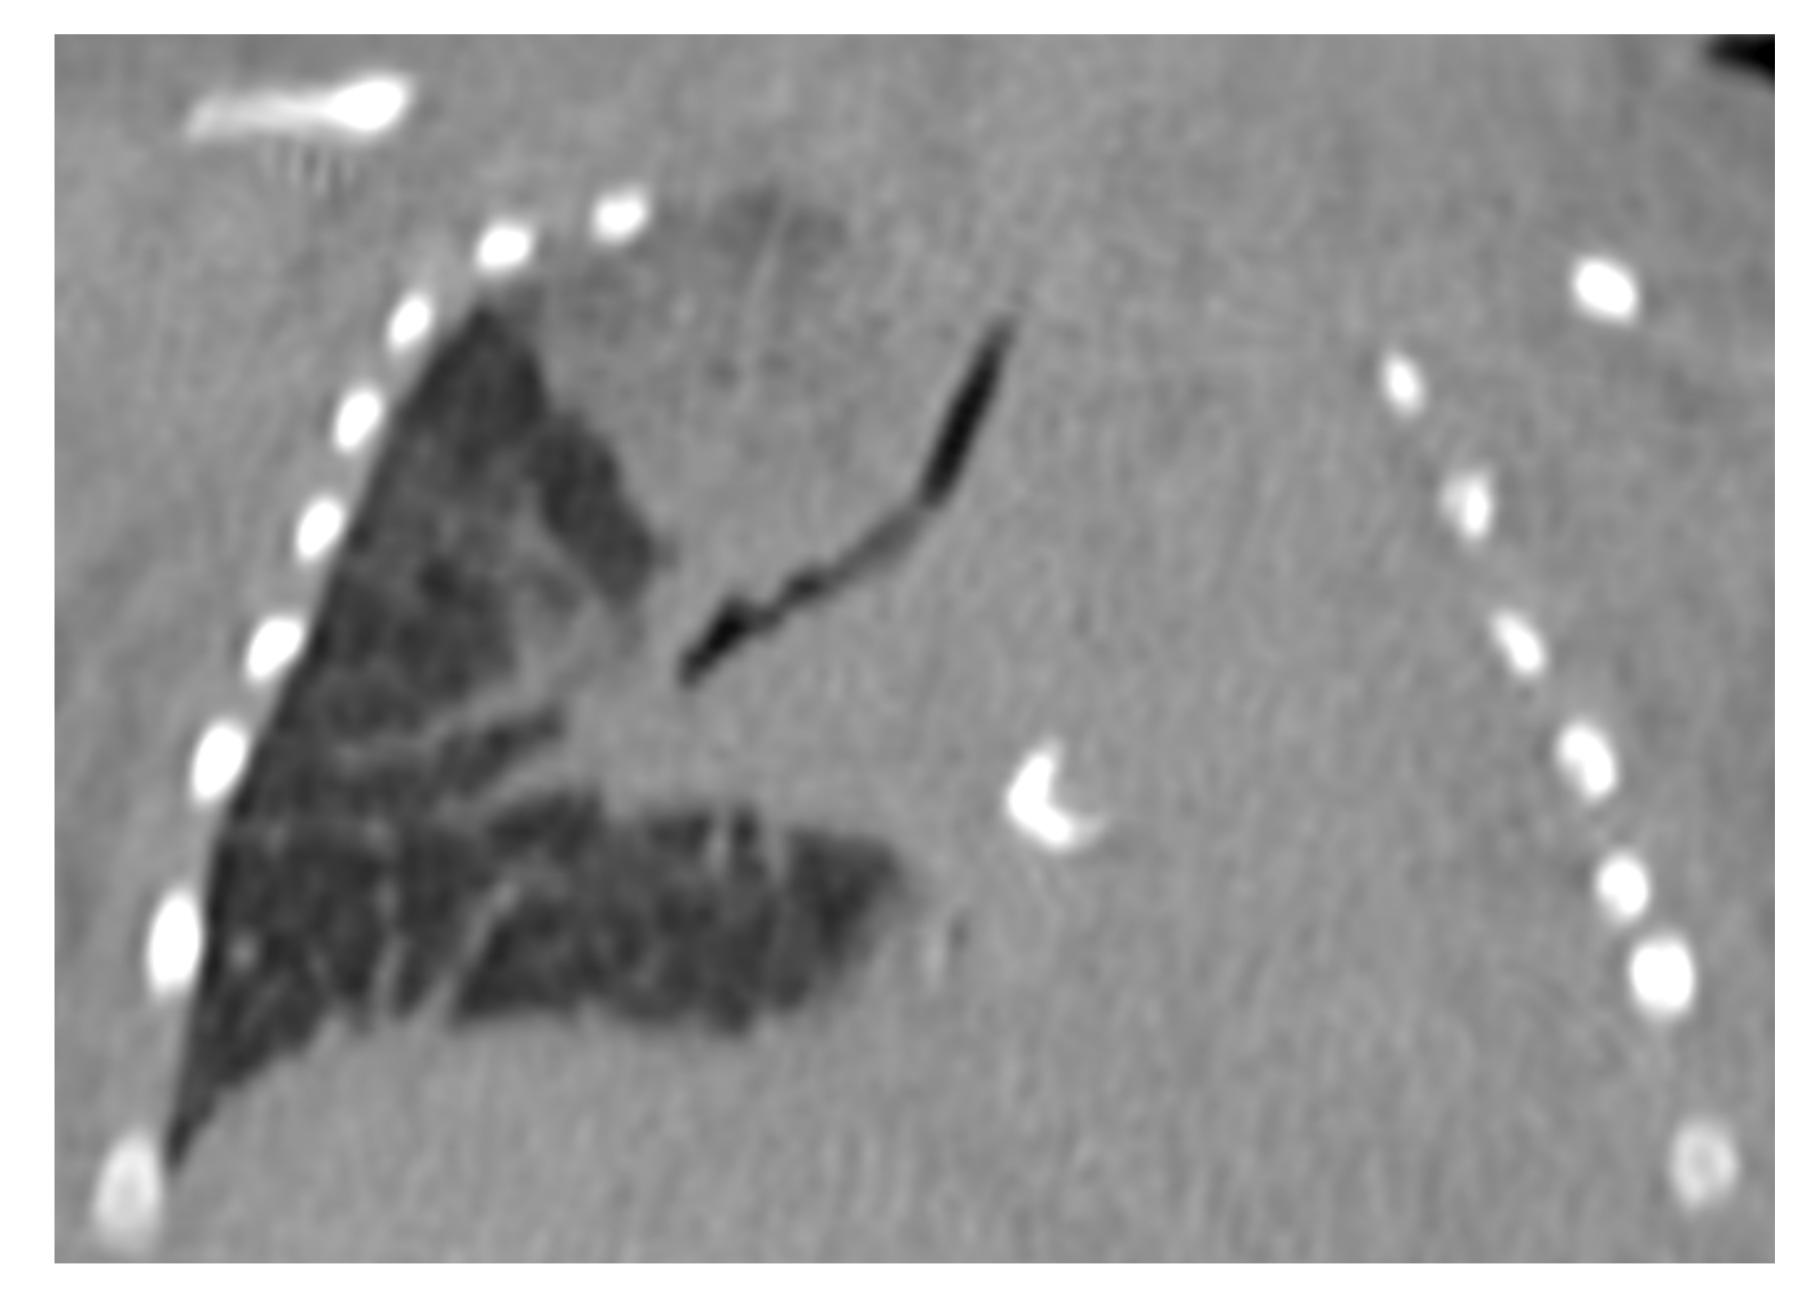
CT chest coronal view showing absence of left lung and left mainstem bronchus
